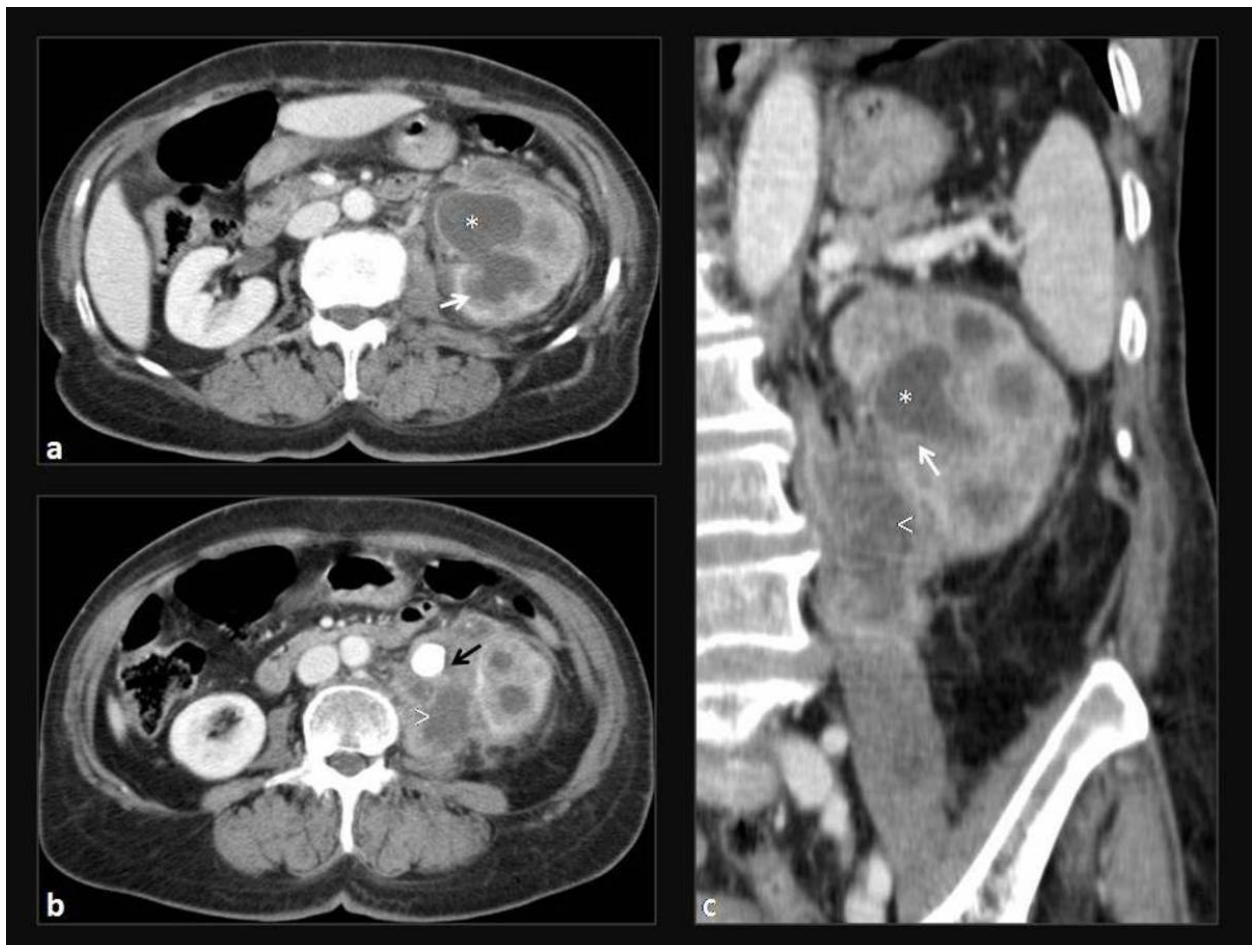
Pyonephrosis. Axial (a and b) and coronal (c) CT images show a dilated collecting system (*) with thickening of its walls (white arrows). There is also a perinephric abscess
